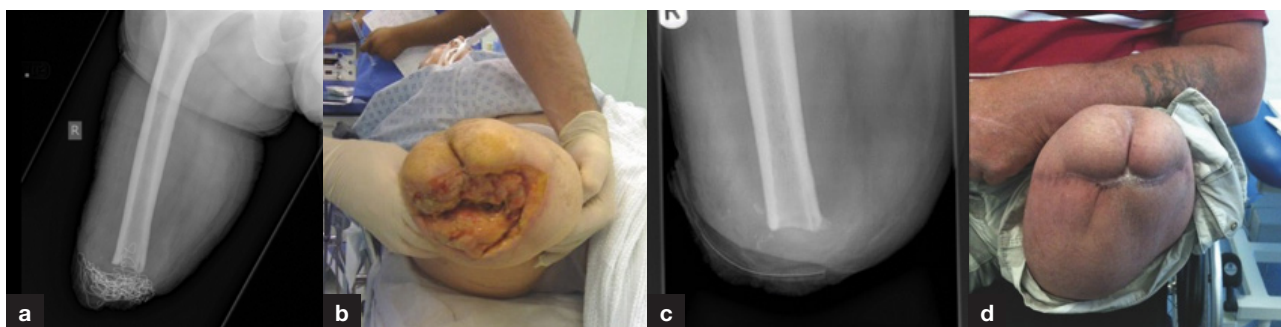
a. Patient with an above-knee amputation for chronic prosthetic joint infection of the knee had recurrence of infection as a result of inadequate initial debridement. This was managed surgically with further debridement and use of negative pressure dressings. b. Infected above-knee amputation stump with a large ulcer. c. Postoperative radiograph of the amputation stump after debridement. d. Healed postoperative amputation stump after debridement and use of negative pressure dressings.
